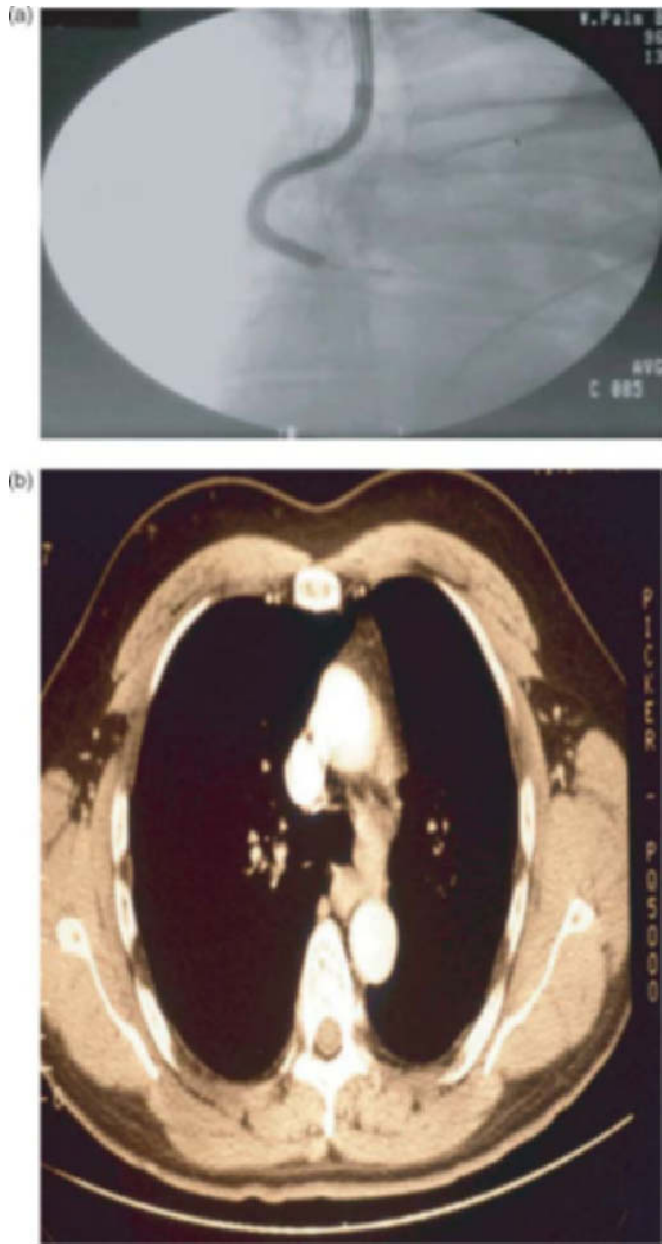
(a) Trans bronchoscopic needle aspiration at station 4 (AP window). Note angle of insertion between aorta superiorly and pulmonary artery inferiorly. (b) Computed tomography scan demonstrating AP window adenopathy.
